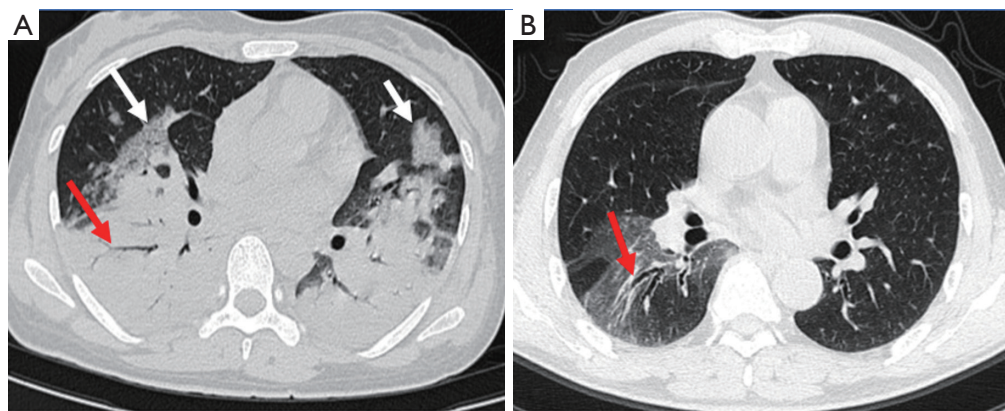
CT signs of CPP. (A) The “fine mesh sign” could be seen in the lesion, which represented the thickening of the interlobular septum, indicating that the lesion was distributed along the interstitium, as shown by the white arrows. In addition, air bronchogram could be observed, and the bronchus was unobstructed, as shown by the red arrow. (B) During the dissipated period of the disease, a few ground-glass shadows could still be observed. In addition, thickened bronchial wall and dilated bronchial lumen were observed inside, as shown by the red arrow. CT, computed tomography; CPP, *Chlamydia psittaci* pneumonia.
